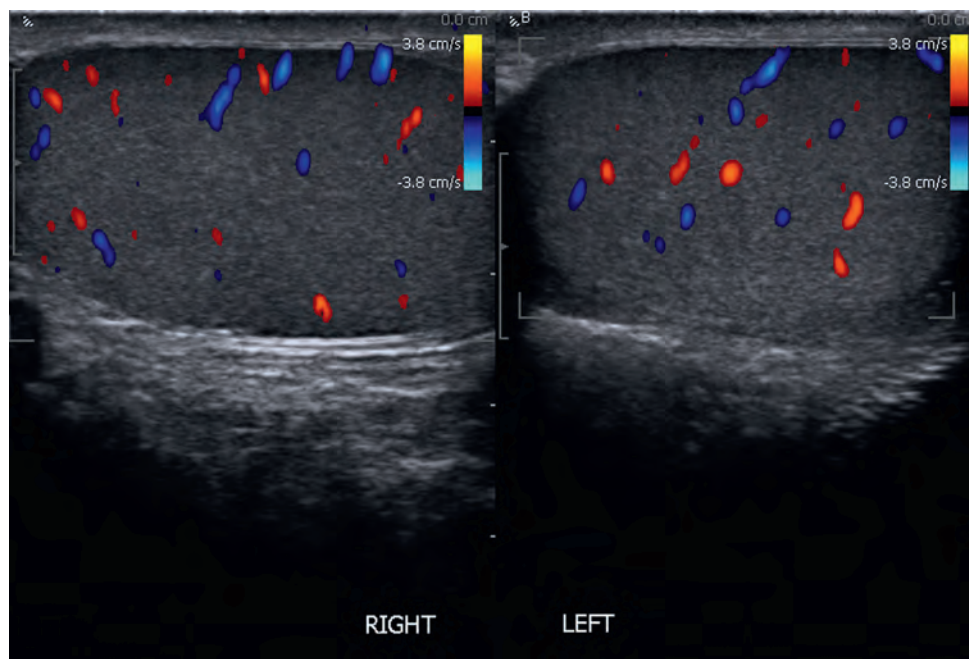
Demonstration of normal bilateral intratesticular blood flow by color Doppler.
